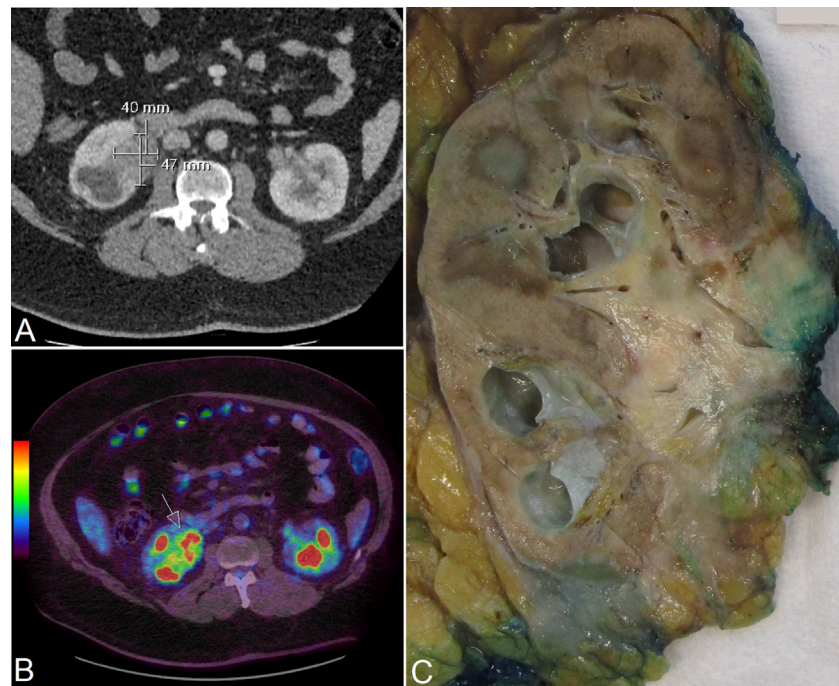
Radiological and macroscopic features. (A) Axial CT: ill-defined right renal hilar lesion. (B) PET-CT: increased FDG activity in lesion. (C) Longitudinal section of right kidney demonstrating the pale hilar mass.
